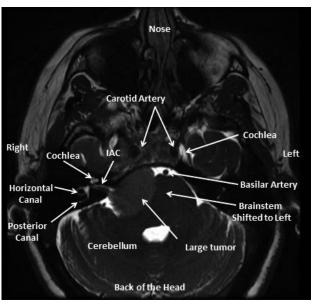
Axial CISS MRI of the patient at the level of the IAC showing no significant mass in the IAC.
